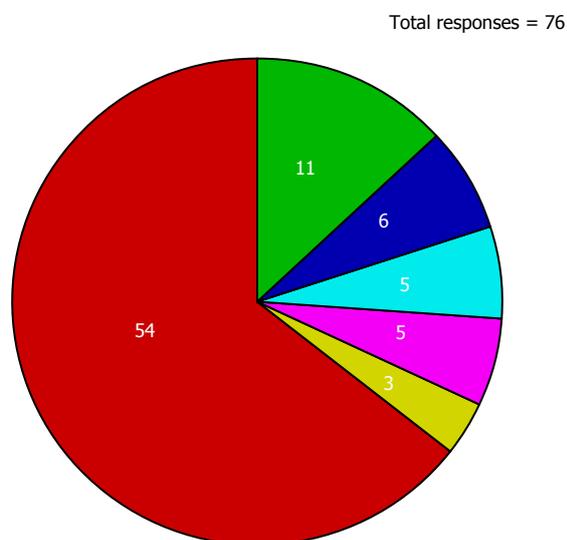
Criteria for referral for a surgical evaluation. GBEF: Gallbladder ejection fraction; CCK: Cholecystokinin; RUQ: Right upper quadrant; CCK-CS: Cholecystokinin scintigraphy scan.
